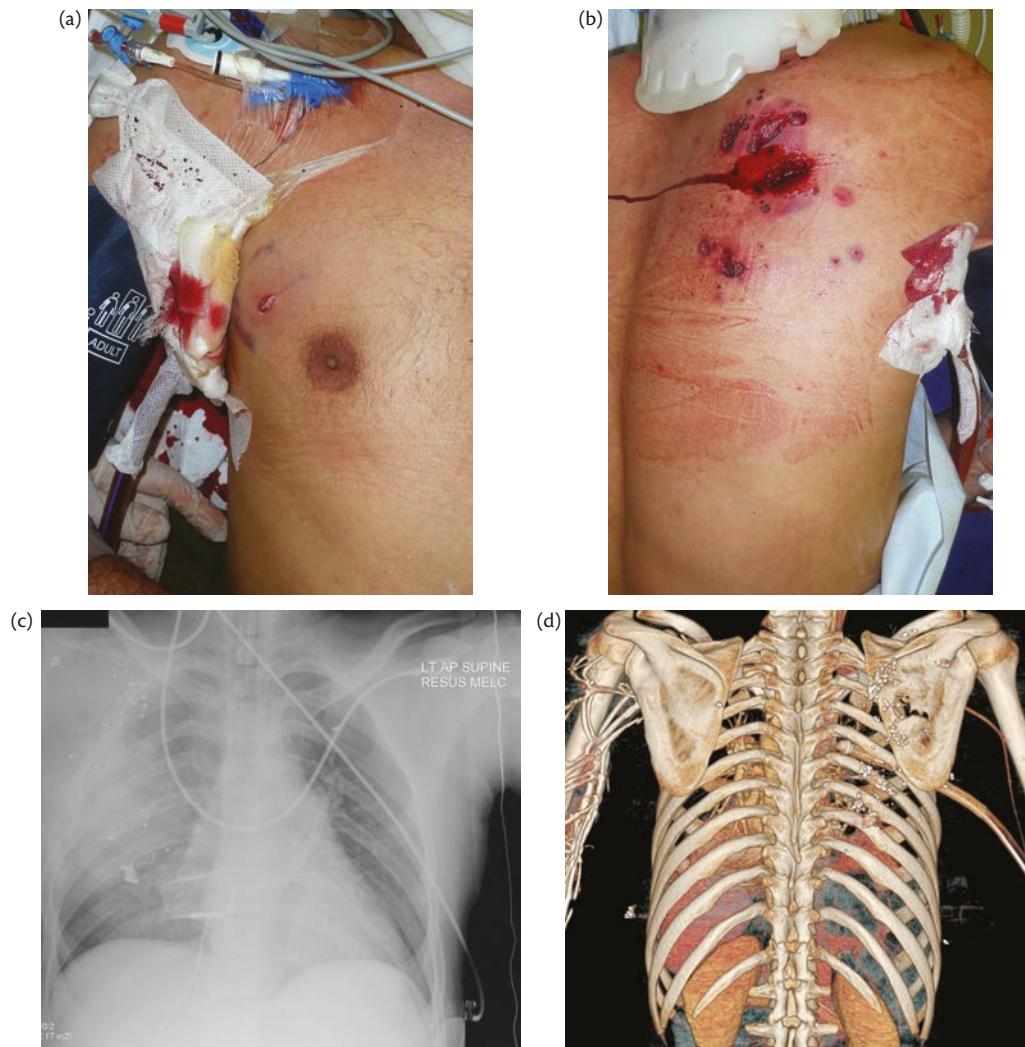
High velocity entry (a), and exit (b) wounds. The entry wound is a neat punched out oval with surrounding bruising, while the multiple exit wounds are due to bullet fragmentation, which can be seen on the chest X-ray (c), and bony fragments from the underlying fractured scapula, as seen on the CT reconstruction (d).
